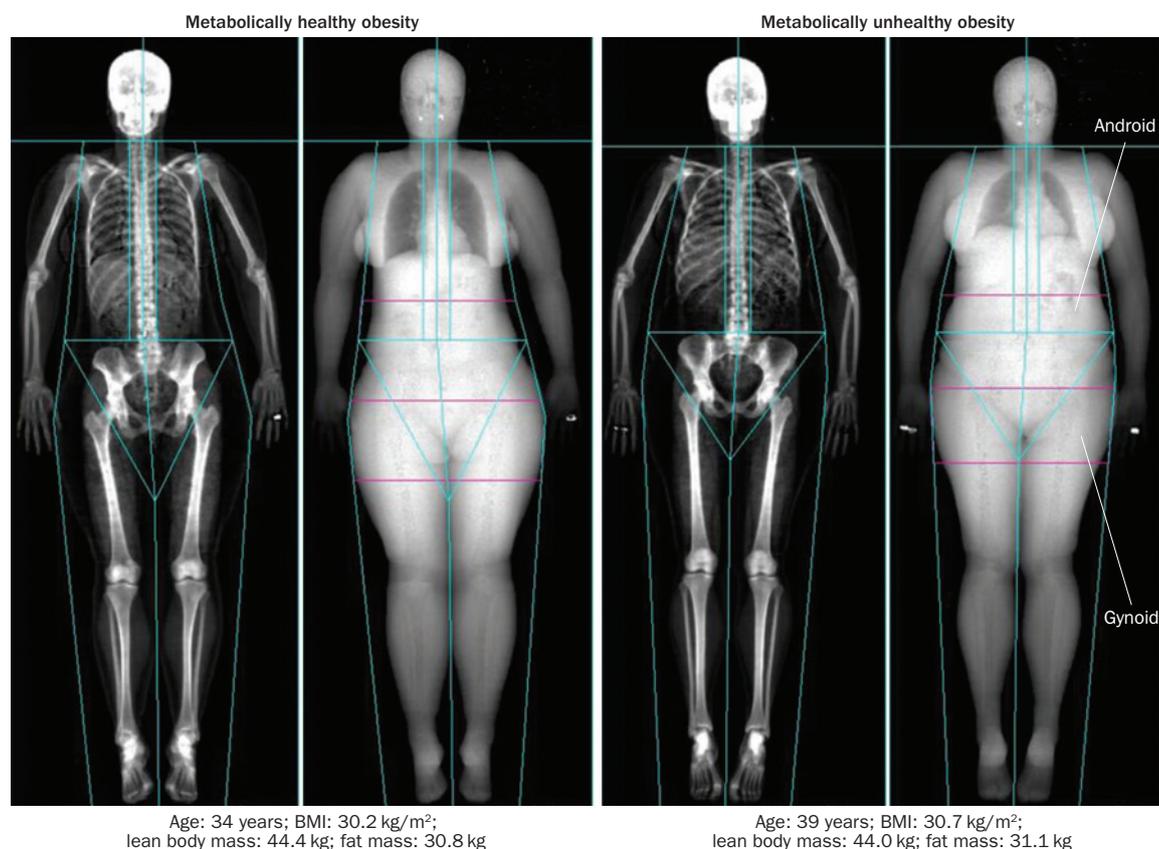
Opposing association between lower-body fat accumulation and metabolically healthy obesity. Body composition analysis by dual-energy X-ray absorptiometry of a representative pair of women with obesity who are matched for age, lean body mass and total fat mass but different for insulin sensitivity (metabolically healthy versus metabolically unhealthy obesity). Women with obesity (30–35 kg/m²) aged 30–50 years ($n=234$) who were participants in the Oxford BioBank²¹ were assigned to quintiles on the basis of fasting serum levels of insulin. Each quintile contained 46 women and 25 pairs matched for age (within 5 years), lean body mass (within 1 kg) and total fat mass (within 1 kg) were selected. Figure shows a representative matched pair of women. An obvious gynoid fat distribution is evident in the metabolically healthy woman (low levels of insulin) compared with the android fat distribution evident in the metabolically unhealthy woman (high levels of insulin). The women whose scans are shown gave consent for their data to be used for research and dissemination of research purposes.
